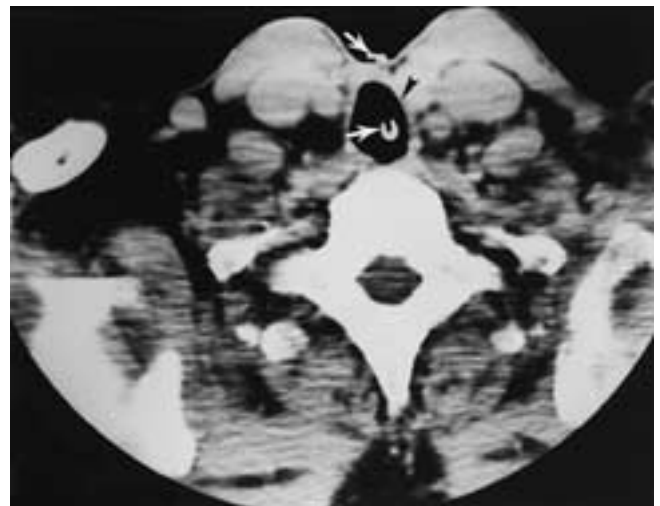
Axial CT, Blom-Singer valve used to pass air from the tracheostomy site into the esophagus. The tube (*arrows*) is too small to be a tracheostomy tube. The apparent airway (*arrowhead*) is actually a gas-filled esophagus. The airway would be seen on a lower scan. If the air-filled structure were the airway, one would expect to see the esophagus just posteriorly.
